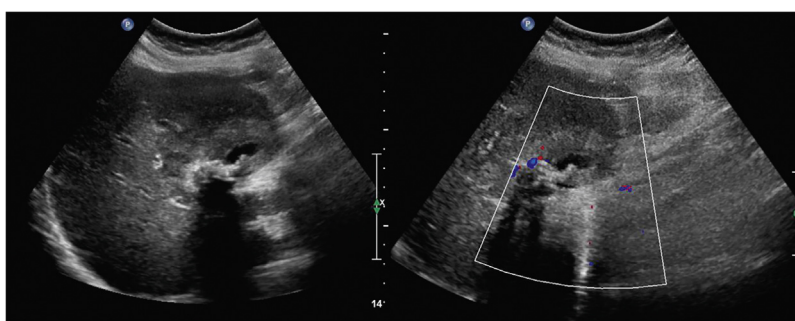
Gray-scale and Doppler US image show GB mass with internal vascularity.
